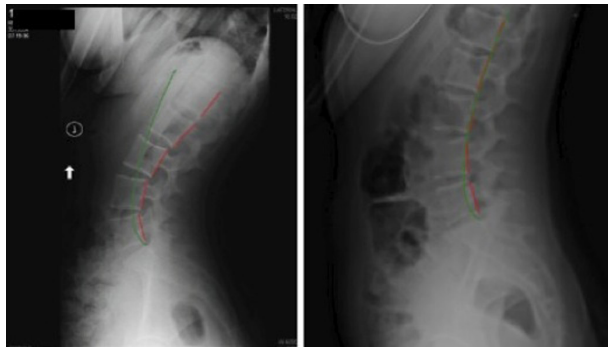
Lumbar spine radiograph
